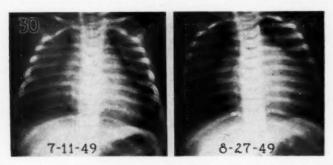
(case 4).—Roentgenogram of the thorax. (a) At 5 months of age there was questionable cardiac enlargement. (b) At 6½ months of age the heart definitely had enlarged.
